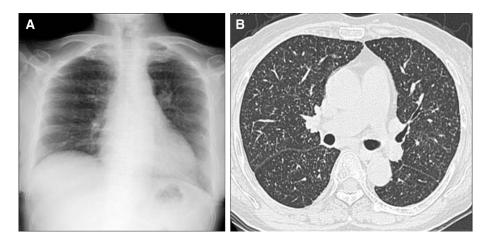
Miliary tuberculosis. Miliary tuberculosis in a 65-year-old woman with cough who had been treated with tocilizumab for 2 years. (A) Chest radiograph and (B) high-resolution computed tomography, showing multiple miliary nodules with random distribution. Diagnosis of miliary tuberculosis is based on bacteriologic detection of *Mycobacterium tuberculosis* from sputum and gastric juice.
